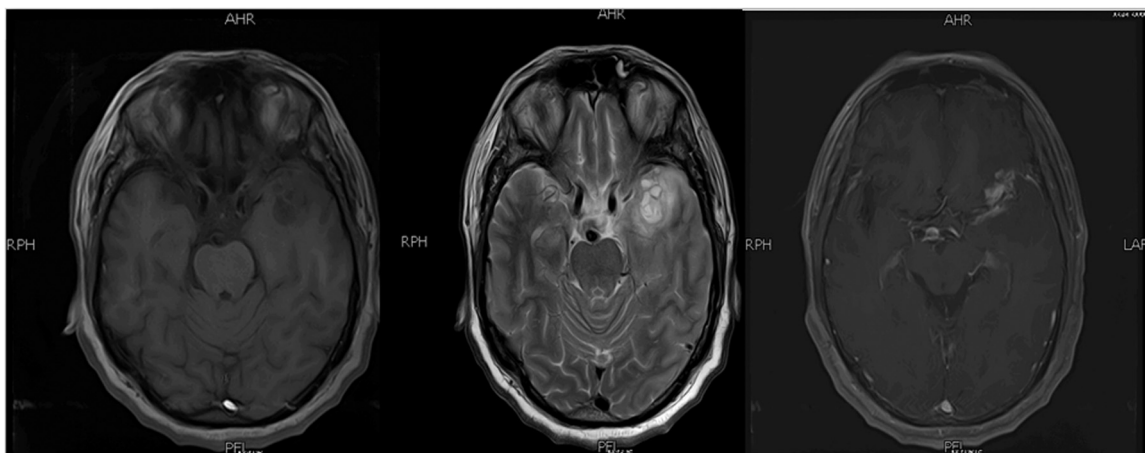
(A) MRI Brain T1 weighted showing hypointense nodular thickening in the left temporal lobe and para sylvian fissure. (B) T2 weighted image showing hyperintense lesion in the left temporal lobe. (C) T1 contrast image showing patchy enhancement in the left temporal lobe.
